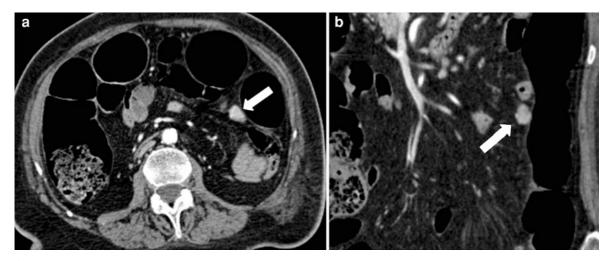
Contrast-enhanced axial (a) and coronal (b) CT image show a small hyperenhanced nodular lesion (*arrow*) of the small bowel wall suggestive for GIST. Note how the lesion (*arrow*) is better appreciable on arterial phase (a) than in venous phase (b)
